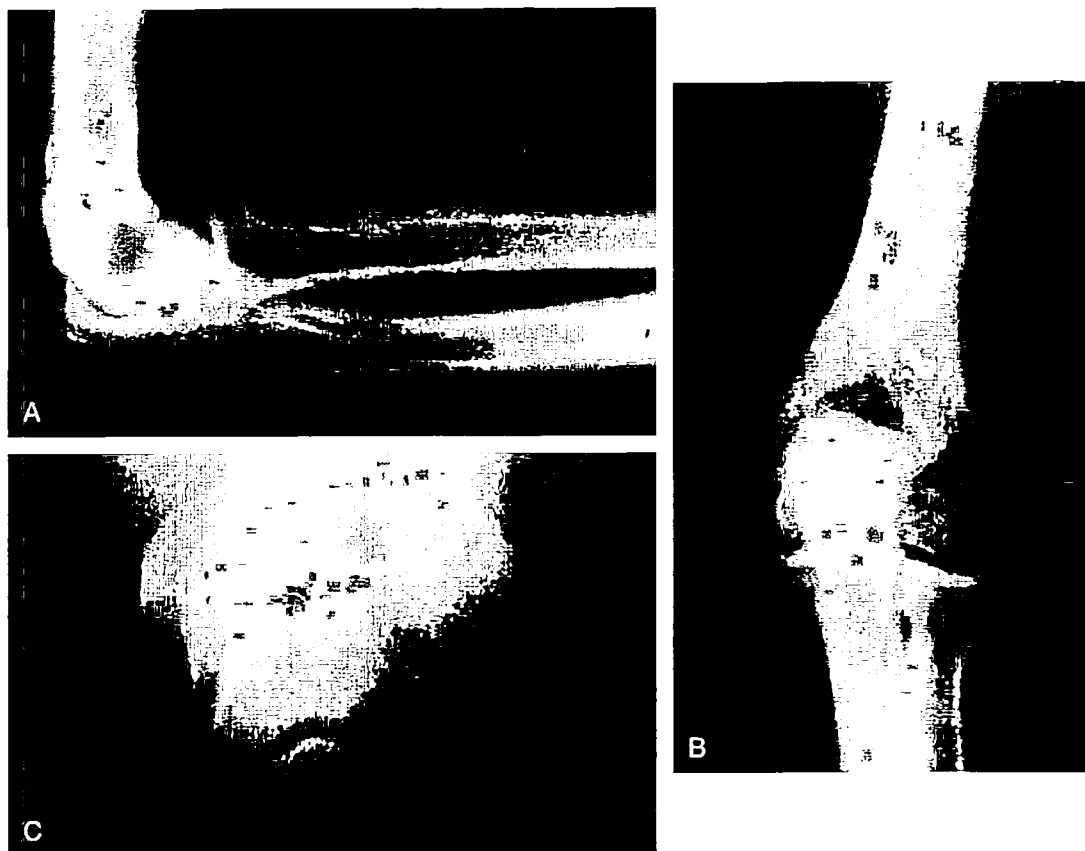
Anteroposterior (A), lateral (B), and axial (C) radiographs of the elbow.
